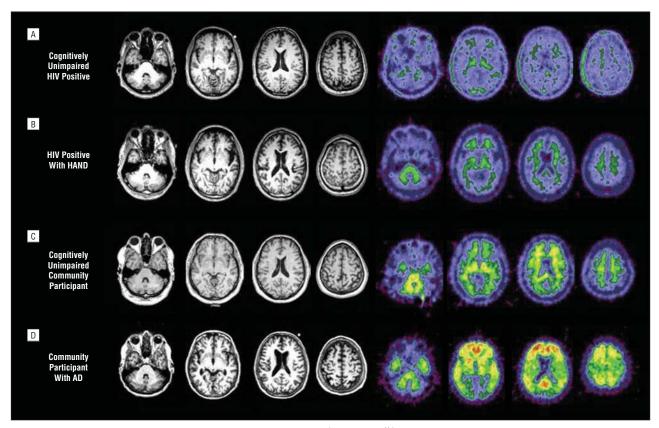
Magnetic resonance imaging (MRI) and carbon 11–labeled Pittsburgh Compound B (11C-PiB) imaging in 4 representative study participants. Representative structural MRIs and 11C-PiB images for a cognitively normal human immunodeficiency virus (HIV)—positive participant (A), an HIV-positive participant with HIV-associated neurocognitive disorder (HAND) (B), a cognitively normal Alzheimer's Disease Research Center (ADRC) participant (C), and ADRC participant with symptomatic Alzheimer disease (AD) (D). Only the symptomatic AD participants had increased fibrillar amyloid deposition using 11C-PiB.
